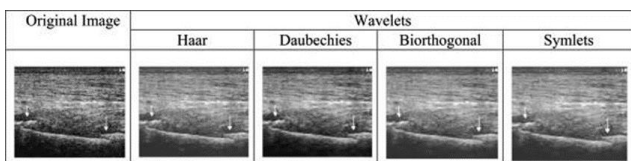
Fibula fracture ultrasound image.
